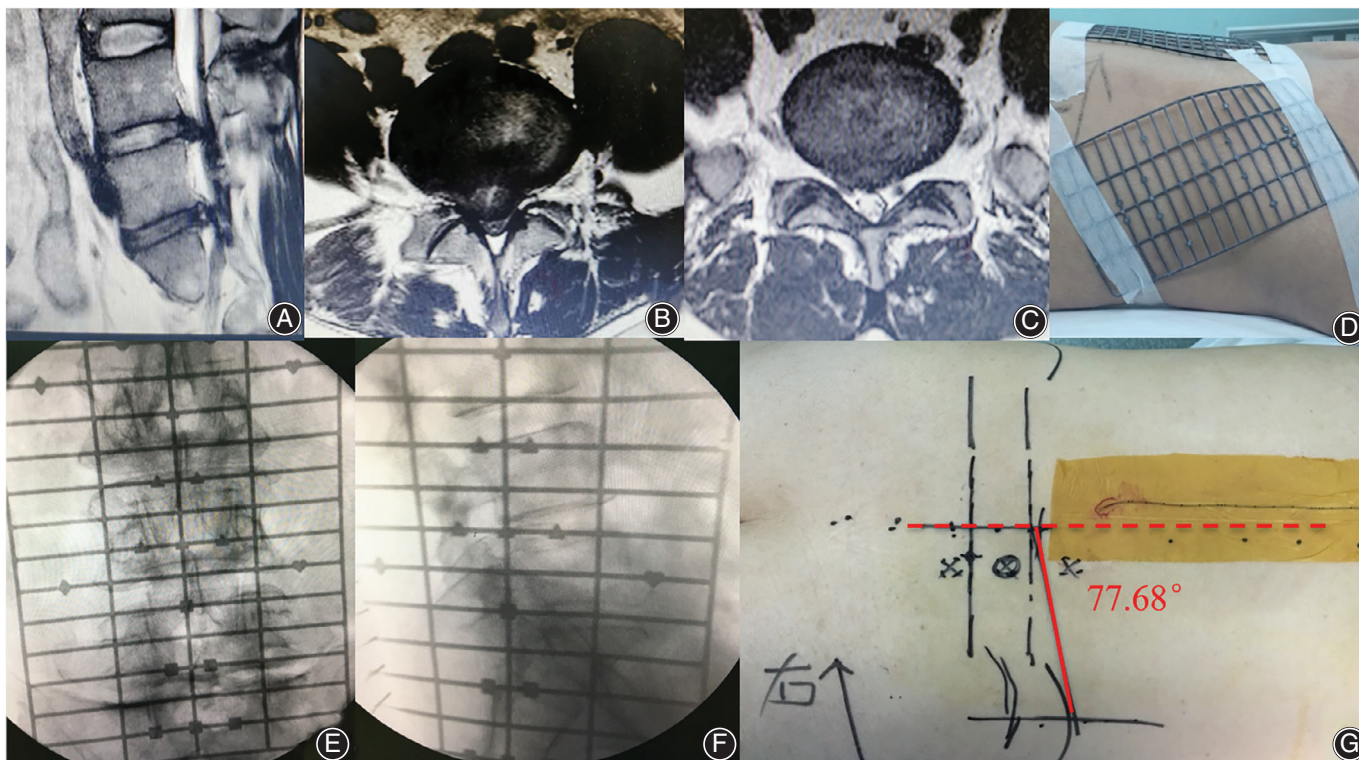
Surface location of percutaneous endoscopic lumbar discectomy (PELD) via the transforaminal approach combined with interlaminar approach for L4/5 and L5/S1 two-level disc herniation. (A–C) MRI of L4/5 and L5/S1 two-level disc herniation. (D) Patients were placed on a radiolucent operating table in a prone position under epidural anesthesia. Surface locators were attached to the posterior and the lateral side of lumbar region. (E, F) Anteroposterior and lateral X-ray view with surface locator. (G) The rough shape of anatomical structures like pedicles and the iliac crest were drawn on skin. Puncture targets and trajectories for both L4/5 and L5/S1 levels were marked on skin.
